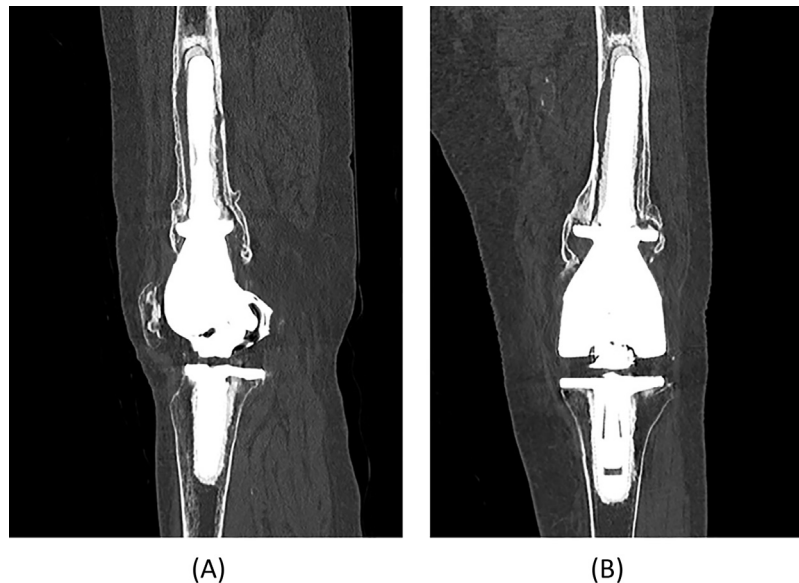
(A) Coronal and (B) sagittal computed tomography images of the knee at 7 years postoperatively.
